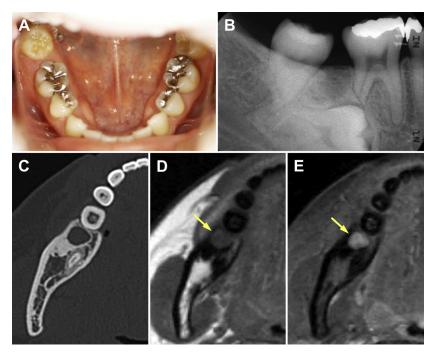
Clinical findings of hybrid ameloblastoma and adenomatoid odontogenic tumor arising in the molar region of the mandible of a 31-year-old Japanese woman. A, Intraoral view. B, Dental radiograph. C, Computed tomography (CT) image, bone window, axial section. D, T1-weighted magnetic resonance image (MRI), axial scan. E, Fat-suppressed contrast-enhanced T1-weighted MRI, axial scan. The patient had a 2-mm space between the right first and third molars of the mandible with the second molar unerupted (A). Radiographically, her second molar was shown to be impacted horizontally in the alveolar bone, and above the impacted tooth there was a round radiolucent lesion. The distal root of the first molar was sharply resorbed (B). CT revealed a spherical unilocular mass between the 2 molars in the mandible (C). T1-weighted MRI showed muscle signal intensity in the lesion (D, *arrow*), but it was significantly enhanced after contrast medium administration (E, *arrow*).
